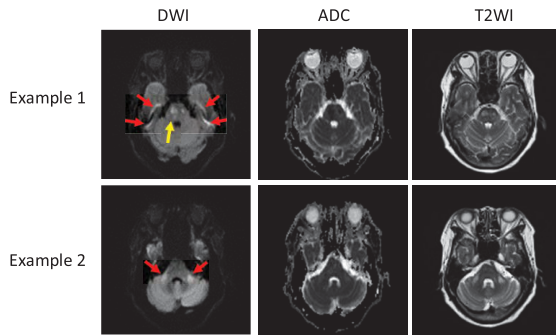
Challenge examples in ischemic stroke segmentation. The columns from left to right shows the DWI, ADC and T2WI. In example 1, the yellow arrow identifies the hyperintense that is a true acute ischemic stroke lesion, and the red arrows identify hyperintense due to magnetic susceptibility artifacts. In example 2, the red arrows identify hyperintense due to T2 shine-through effect. Best view in color.
